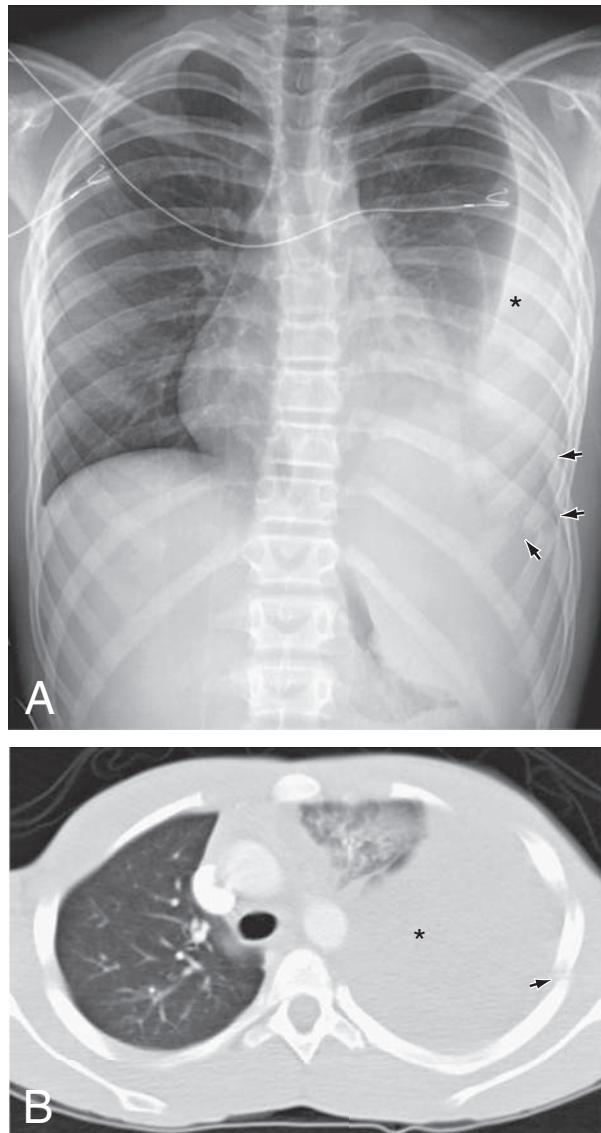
Chest radiograph (A) and CT scan (B) of hemothorax (asterisk) and associated rib fractures (arrows) in a teenager involved in a motor vehicle accident.
